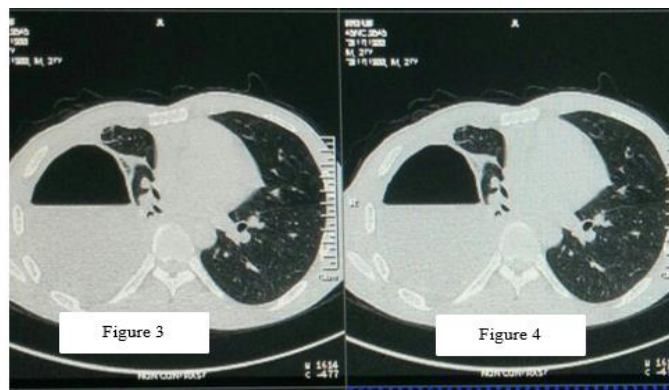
CT scan image of the patient's thorax (axial section)
